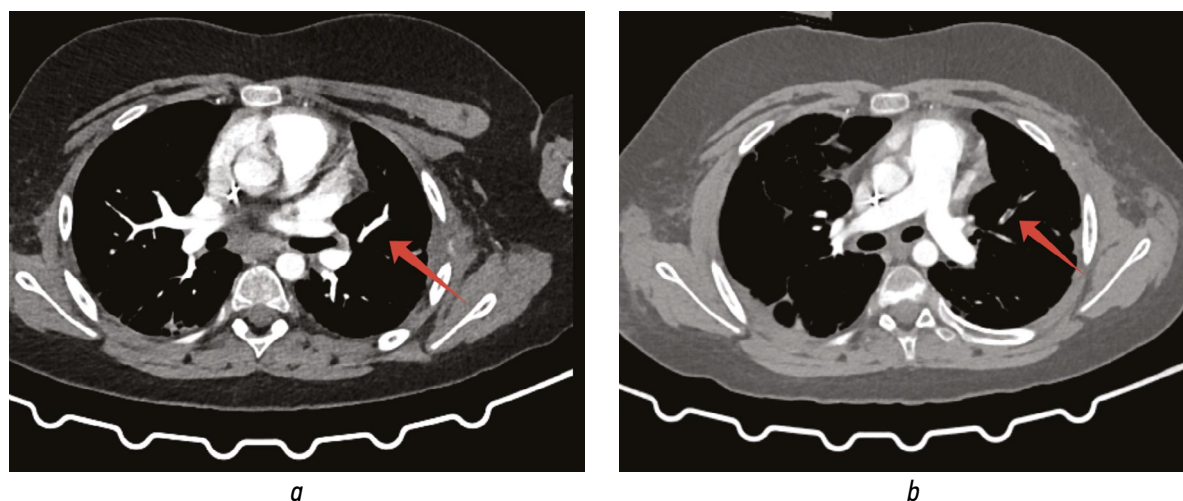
Comparison of computed tomographic pulmonary angiography images before (a) and after surgery (b). Arrow indicates the segmental branch of the left pulmonary artery without a filling defect and with a filling defect following pulmonary embolism.
